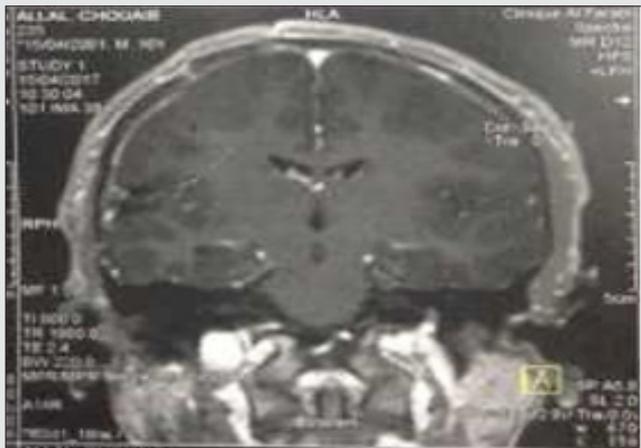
coronal T1 MRI demonstrating right parietal tumor.
